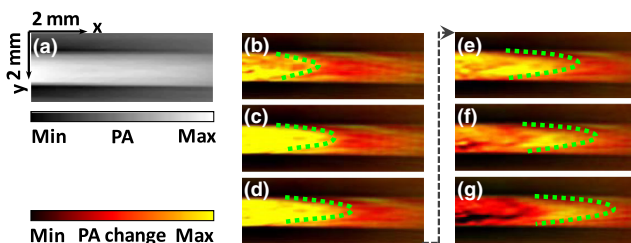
(color online). (a), A typical photoacoustic image of blood flow without ultrasonically encoding. (b)–(g), Ultrasonically encoded photoacoustic flow images of whole blood in a tube. Time interval between adjacent images is 1.6 sec. Dashed line highlights a parabolic heating peak propagating with blood flow.
